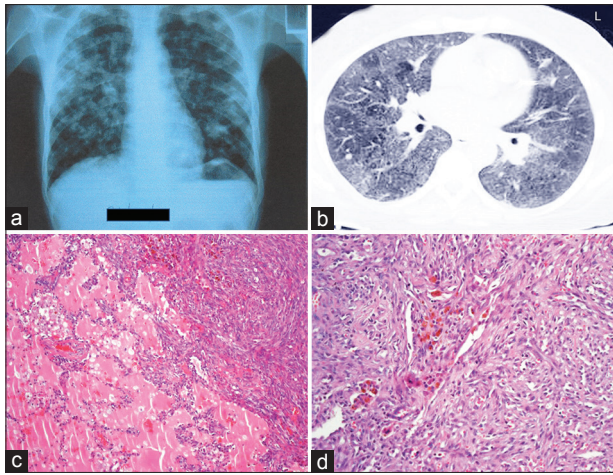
(a) Chest X-ray showing a patchy bilateral alveolar pattern with a tendency toward the formation of condensations. (b) Thoracic computed tomography showing interlobular thickening with intralobular septal lines and ground glass opacities ("crazy-paving" pattern). Marked peribronchovascular thickening and parenchymal nodularity is also observed. (c) Lung biopsy. The alveolar spaces are occupied by a dense and eosinophilic material containing cells corresponding to alveolar macrophages that are loaded with lipid vacuoles.
